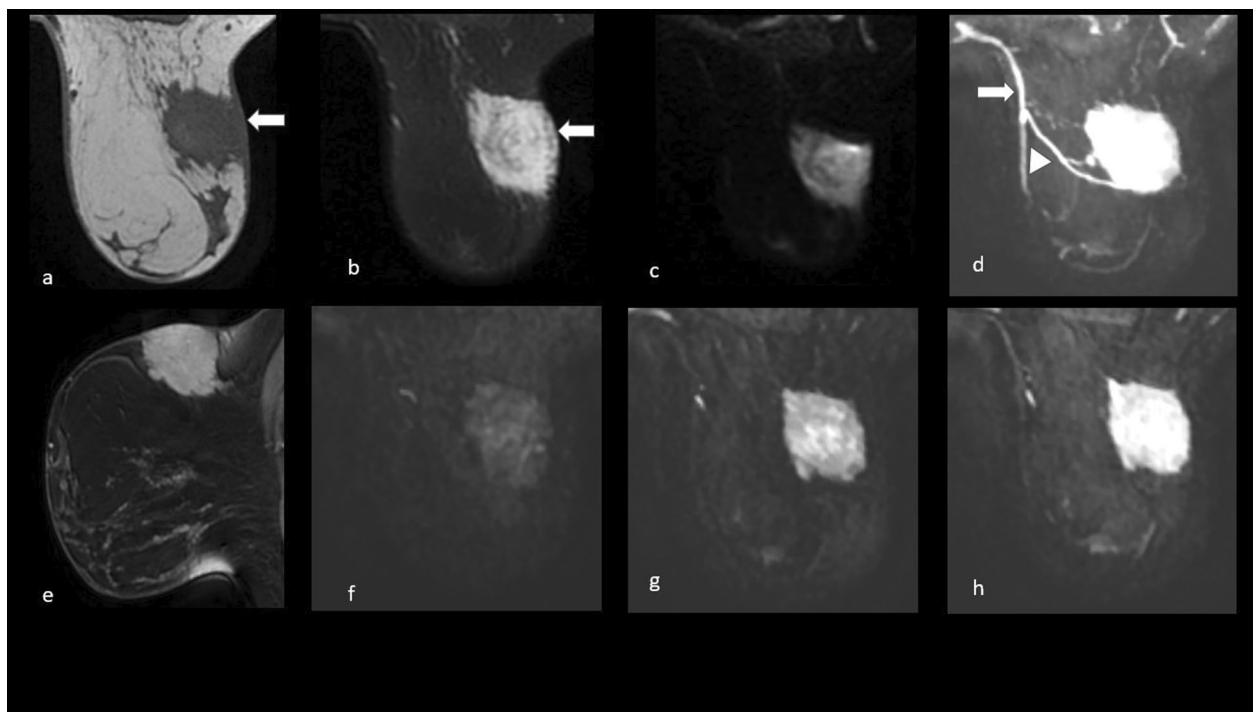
MRI of breast showed a a circumscribed irregular T1 hypointense, b T2/STIR hyperintense lesion in upper outer quadrant at 10–11 o'clock position, closely abutting the skin (white arrows) with associated overlying skin thickening. c Lesion shows DWI restriction. d On maximum-intensity projection images, large feeding vessels arise (white arrow head) from internal mammary artery (white arrow). e T1 sagittal contrast shows homogeneously enhancing lesion in the upper quadrant. f T1 contrast early phase shows contrast uptake. g, h Enhancement progresses to intense heterogeneous enhancement in later phases
